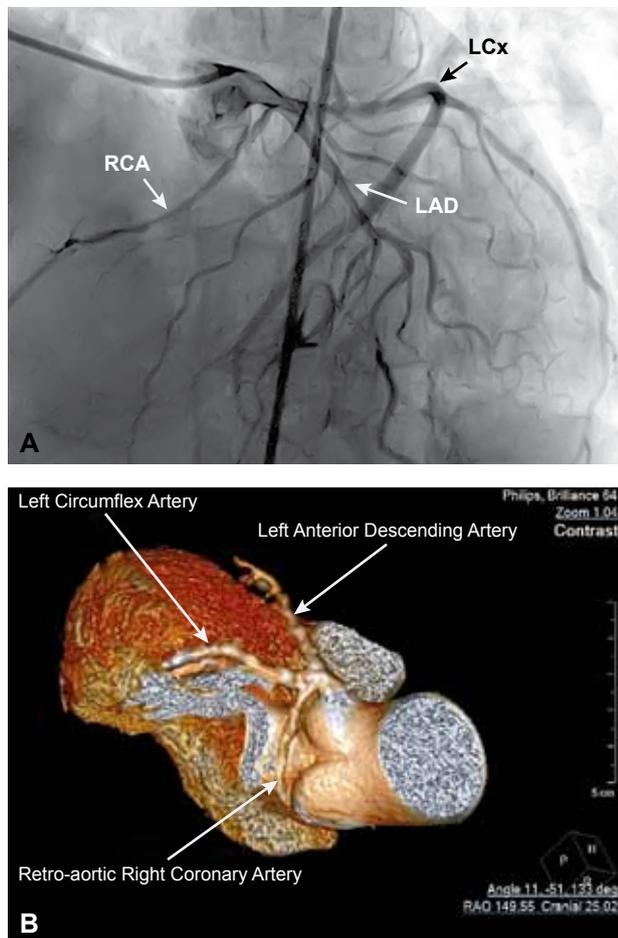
A. Coronary angiogram showing a single coronary artery from the left sinus. B. CT coronary angiogram showing the retro-aortic course of the right coronary artery. LAD – left anterior descending; LCx – left circumflex; RCA – right coronary artery.
